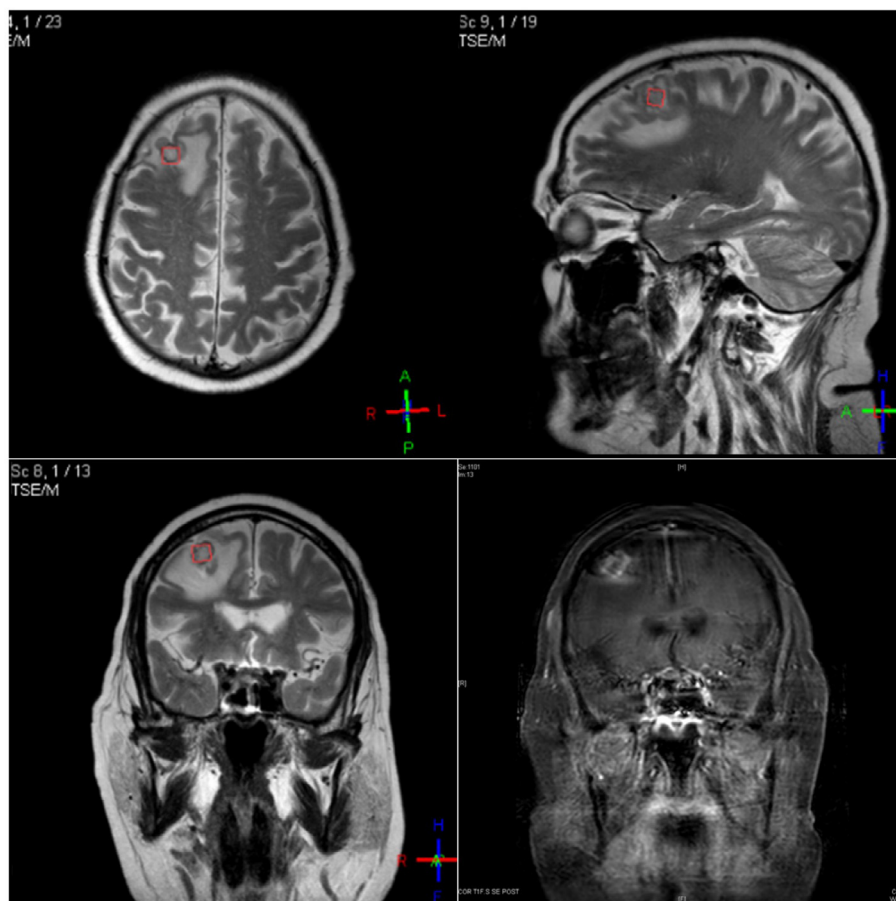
Brain MRI showing right frontal lobe abscess which showed *Aspergillus* in aspiration of abscess.
